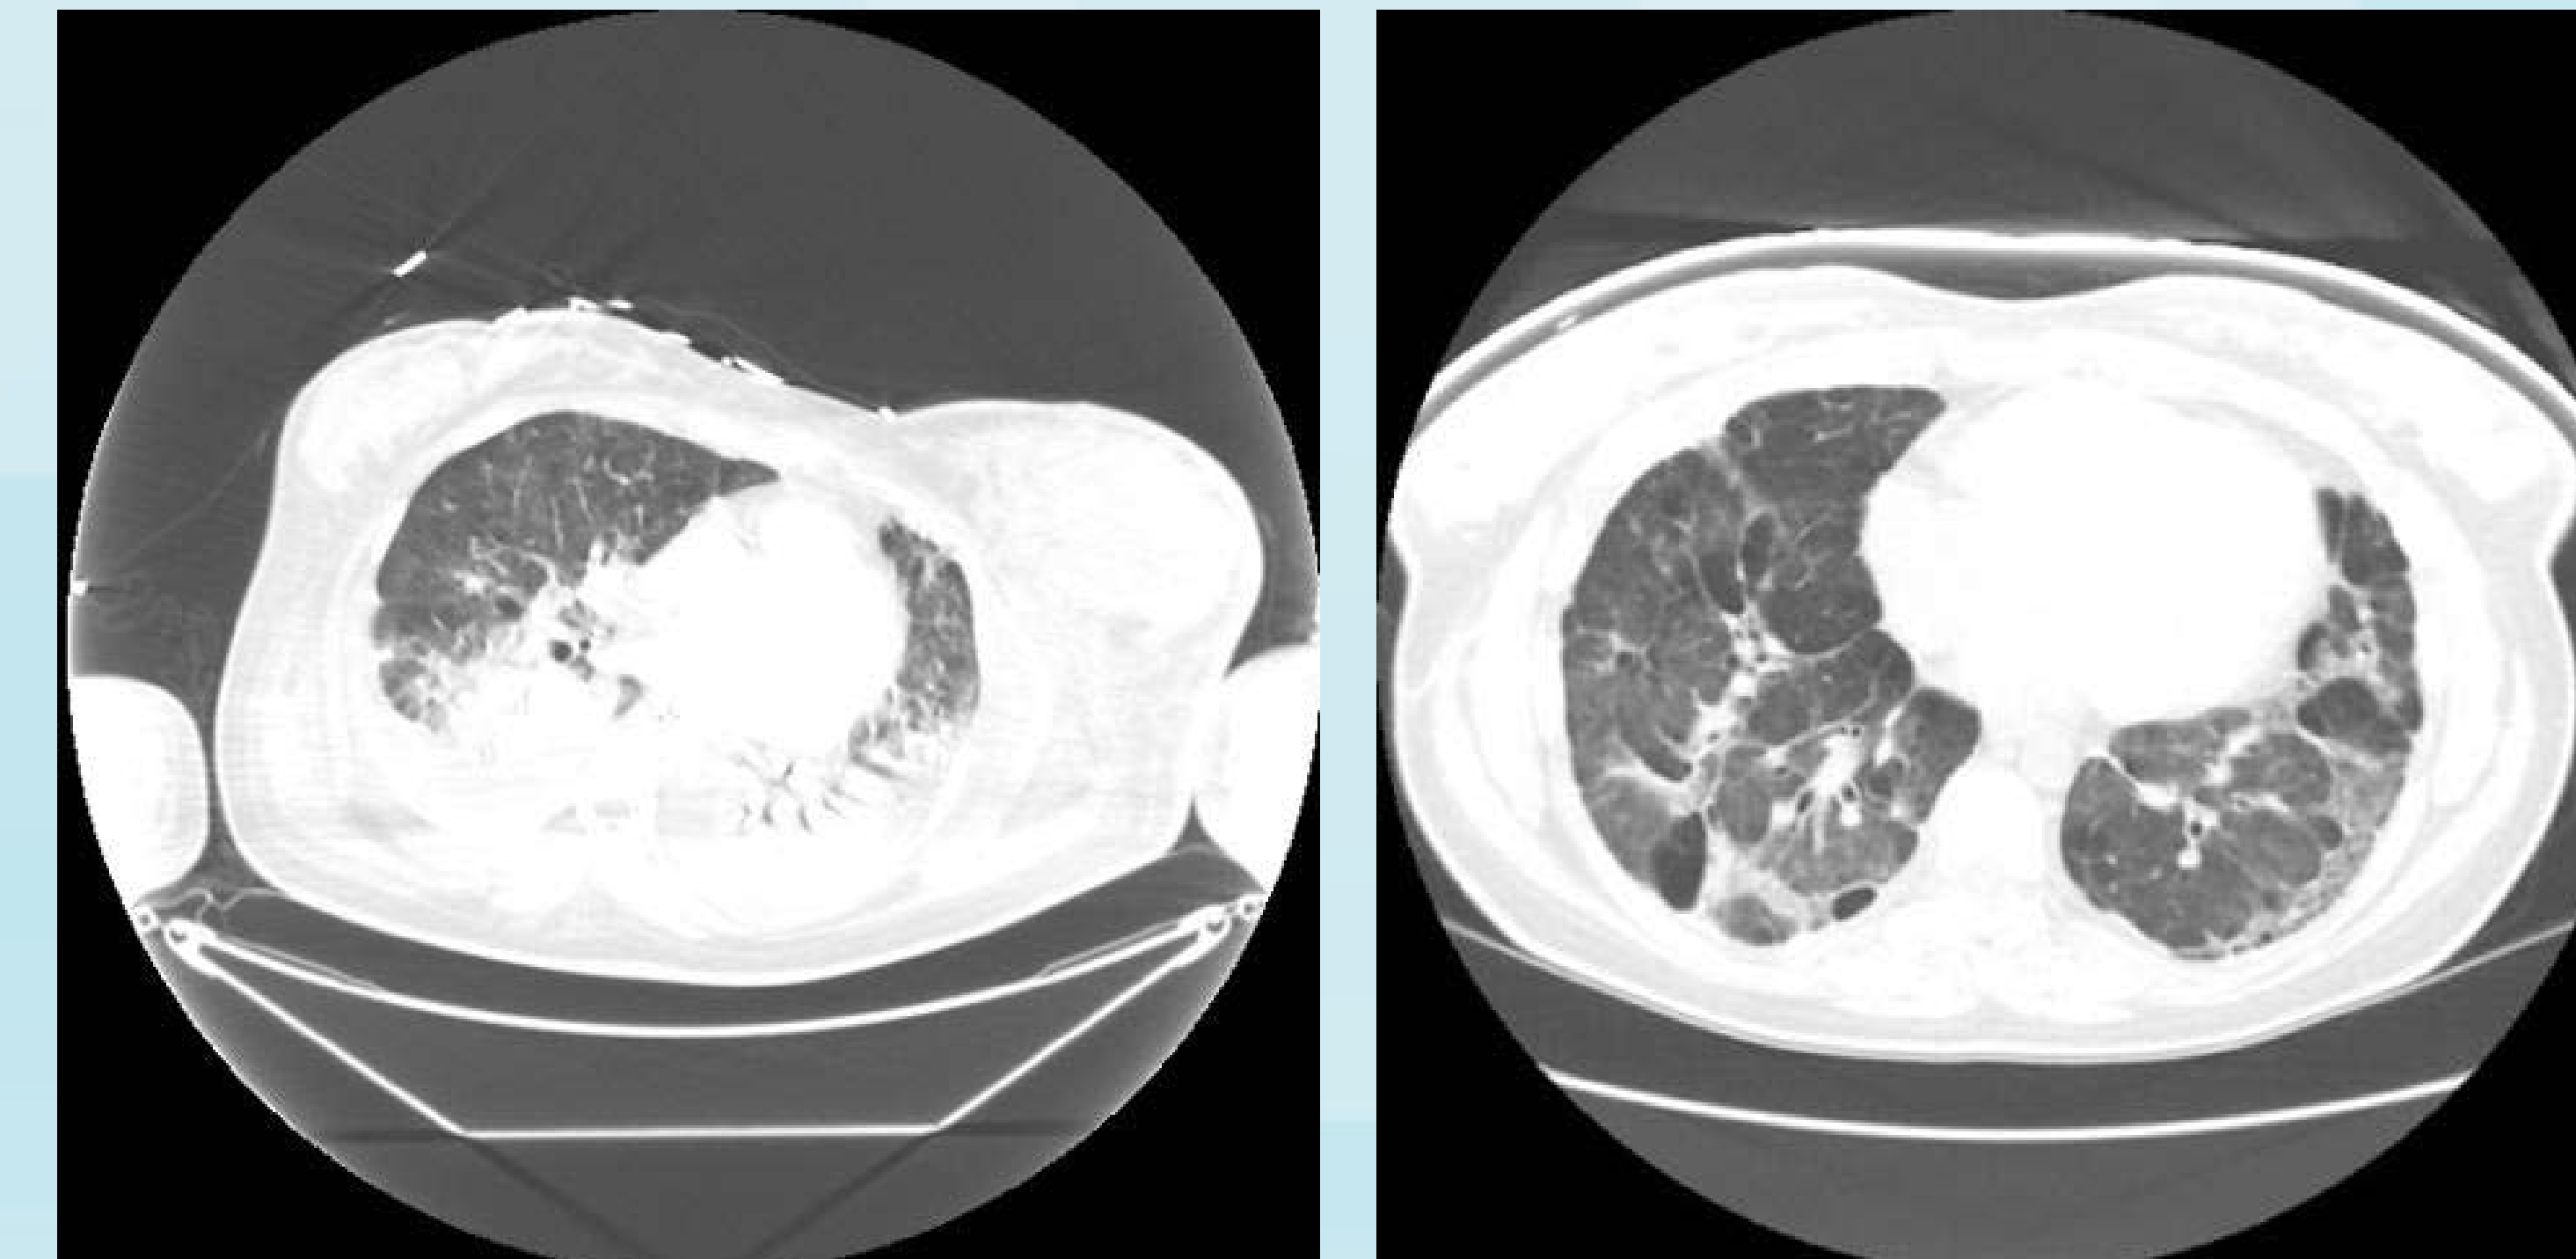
(Patient C) 61 year old male with community acquired pneumonia initial chest CT scan on the left side. The follow up chest CT scan 18 days post ECMO is on the right side.
